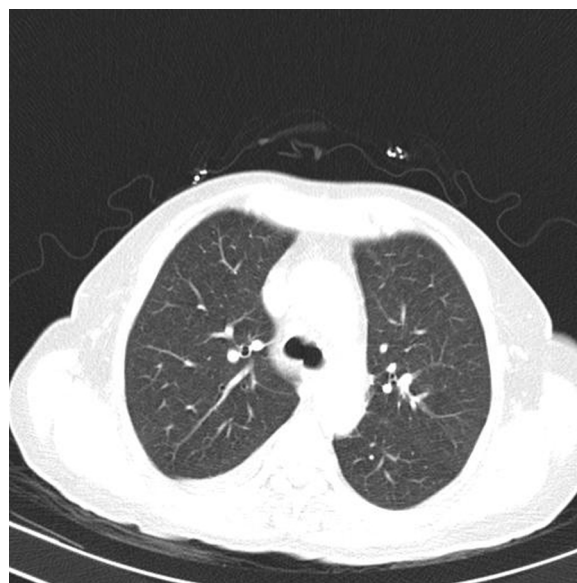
Thorax computed tomography, treated pneumonia.
